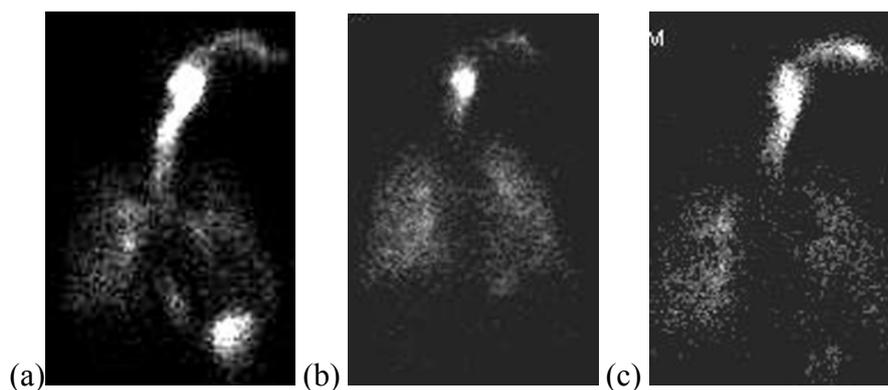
Anterior scintigraphic images of total body distribution of ^{99m}Tc -HFA-FP. (a) Child aged 6 years with 'tidal'. (b) Child aged 9 years with 'breath hold'. (c) Child aged 13 years with 'tidal'.
